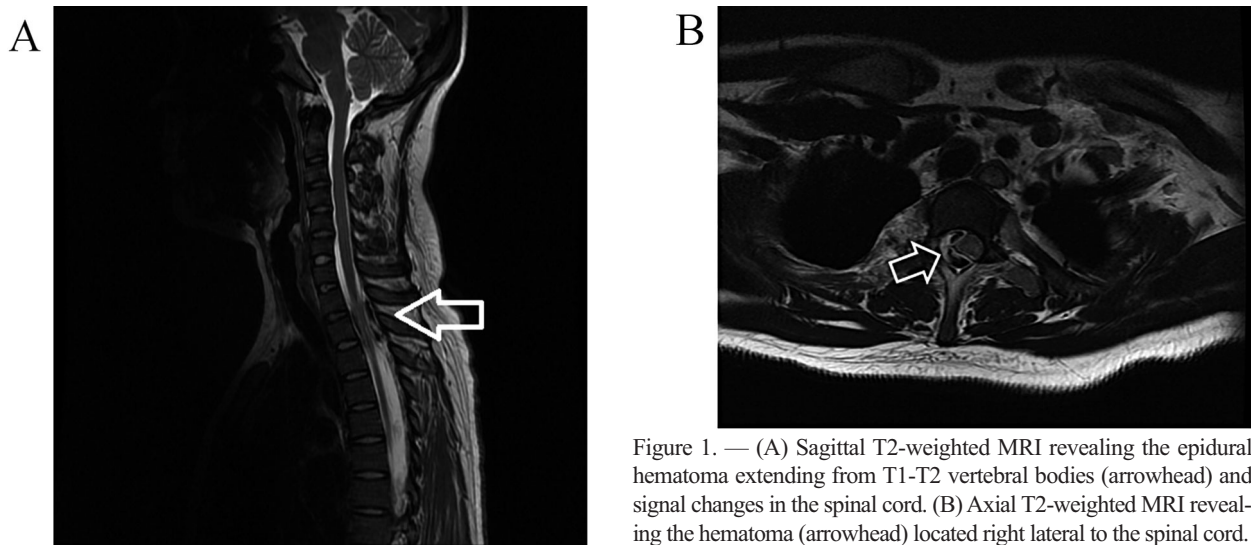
(A) Sagittal T2-weighted MRI revealing the epidural hematoma extending from T1-T2 vertebral bodies (arrowhead) and signal changes in the spinal cord. (B) Axial T2-weighted MRI revealing the hematoma (arrowhead) located right lateral to the spinal cord.
